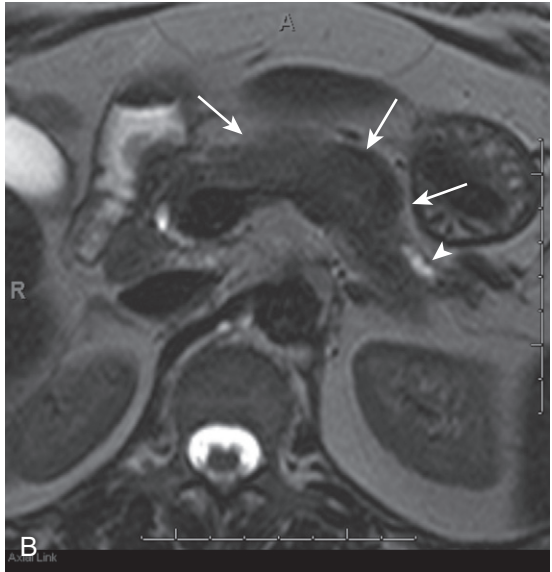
Pancreatic adenocarcinoma—arterial phase imaging. Infiltrative mass enlarges the body of the pancreas (*arrows*), which can be seen on the in-phase T1-weighted (A) and the precontrast fat-suppressed T1-weighted gradient recalled-echo (D) images in contrast to the normal pancreatic parenchyma in the head of the pancreas. This mass demonstrates mildly increased signal intensity on T2-weighted imaging (B), which is pronounced on fat-suppressed T2-weighted imaging (C). In addition, distal gland atrophy and duct dilatation (*arrowheads*) can be seen on the T2-weighted (B) and fat-suppressed T2-weighted (C) images. Furthermore, this mass demonstrates decreased enhancement when compared with the normal pancreas, most pronounced on early arterial phase fat-suppressed T1-weighted gradient recalled-echo imaging (E), with gradual enhancement on delayed phase fat-suppressed T1-weighted gradient recalled-echo imaging (F) related to desmoplastic content.
